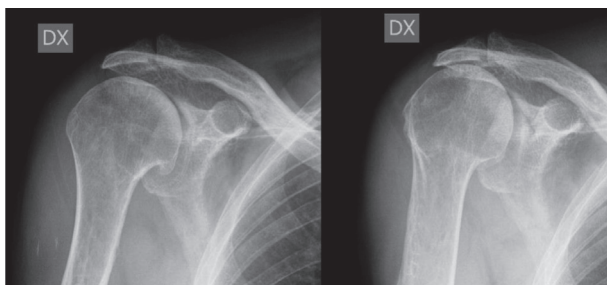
“Cuff tear arthropathy” (CTA) characterized by a massive rotator cuff tear that gradually leads to Eccentric Osteoarthritis
